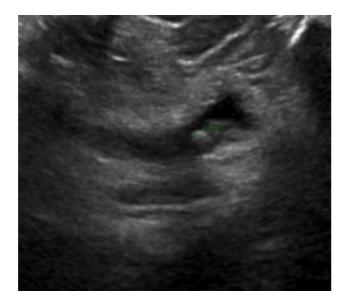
Ultrasound of the kidney and urinary tract, BILATERAL (initial)
